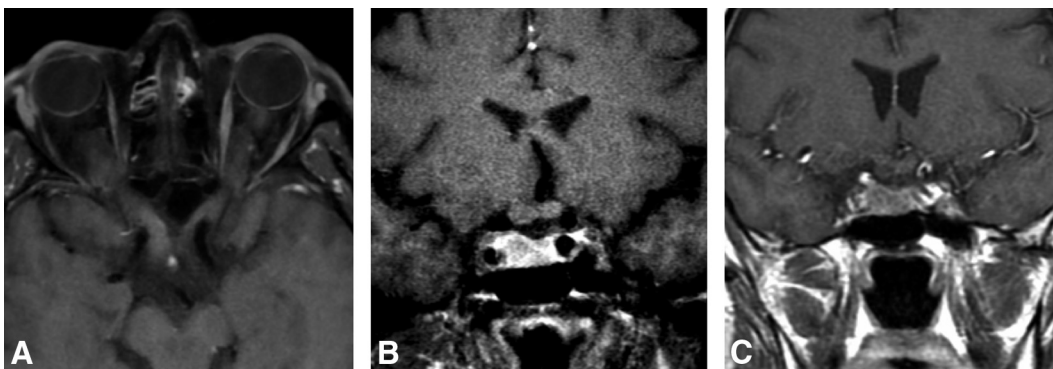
Bilateral optic nerve glioma. Postgadolinium axial (A) and coronal (B) T1WIs with fat saturation, and coronal (C) postgadolinium T1WI in a patient with a bilateral optic nerve and chiasm glioma. A 53-year-old man with a history of vision deterioration. MR imaging demonstrates a bilateral optic nerve glioma with retro-orbital extension and involvement of the optic chiasm.
